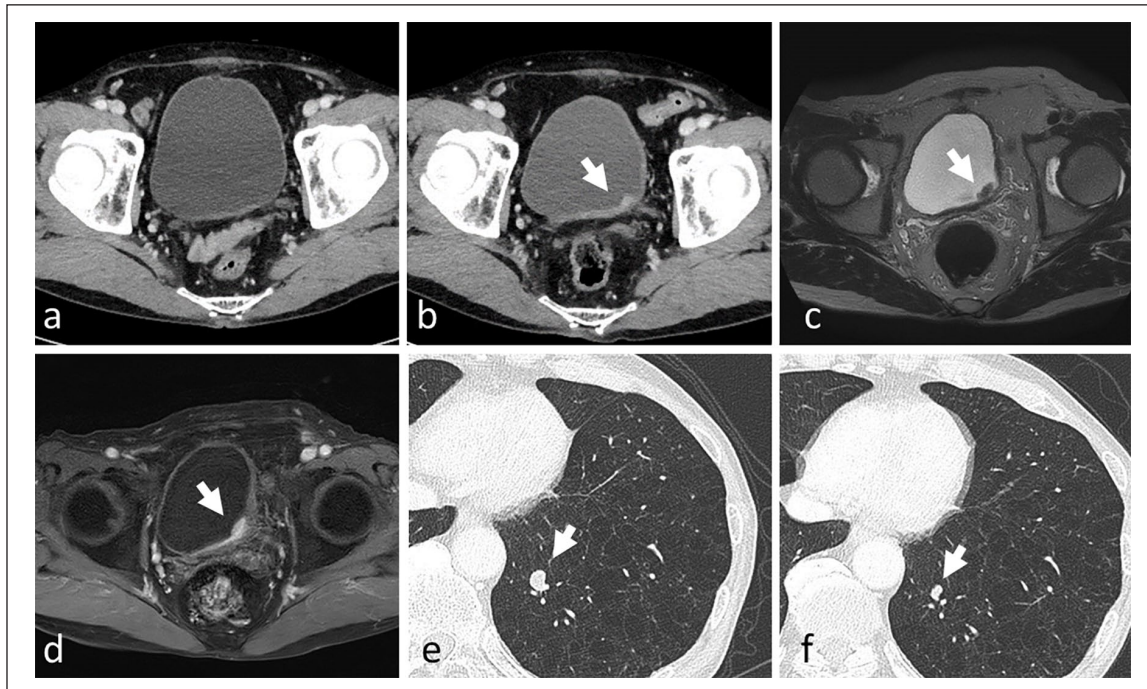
CT and MRI findings. (a) CT reveals no abnormal findings in July 2017. (b) CT reveals the contrast-enhanced wall thickening near the left ureteral orifice in December 2017 (arrow). (c) T2-weighted image of MRI reveals that the tumor in the vicinity of the left ureteral orifice is a low signal lesion without obvious muscle invasion in January 2018 (arrow). (d) On dynamic contrast enhancement imaging, the lesion demonstrates early uptake at the same lesion as the T2-weighted image (arrow). (e) CT findings suspect metastasis in the left lower lobe of the lung in July 2018 (arrow). (f) CT findings reveal a decrease in the size of the nodules in the left lower lobe in September 2018 (arrow).
